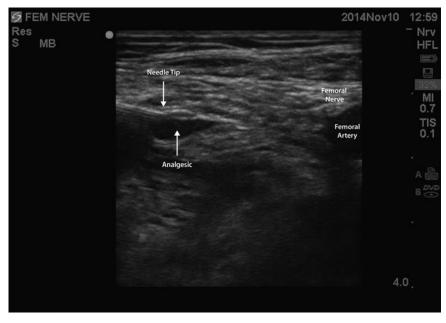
Ultrasound-guided right femoral nerve block.
